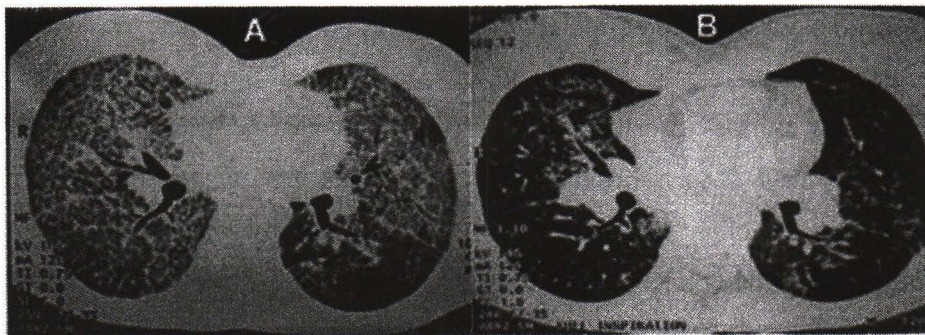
High-resolution CT scan of the thorax in this patient.
